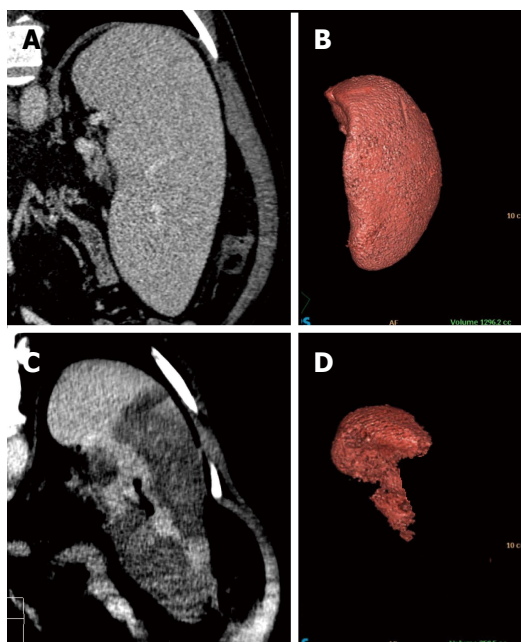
Coronal reformatted contrast-enhanced computed tomography and 3D volumetric reconstruction of the spleen before (A and B) and after (C and D) radiofrequency ablation. Observe the homogeneous splenic parenchyma (A) showing a volume of 1296.2 cc (B) before treatment. After ablation, note the heterogeneity of the spleen (C), with multiple areas of coagulative necrosis mainly concentrated in the middle and lower thirds, saving the splenic hilum and its upper third. After ablation, the volumetric 3D reconstruction confirmed treatment success, leaving approximately 30% of viable parenchyma (volume of 359.5 cc) (D).
